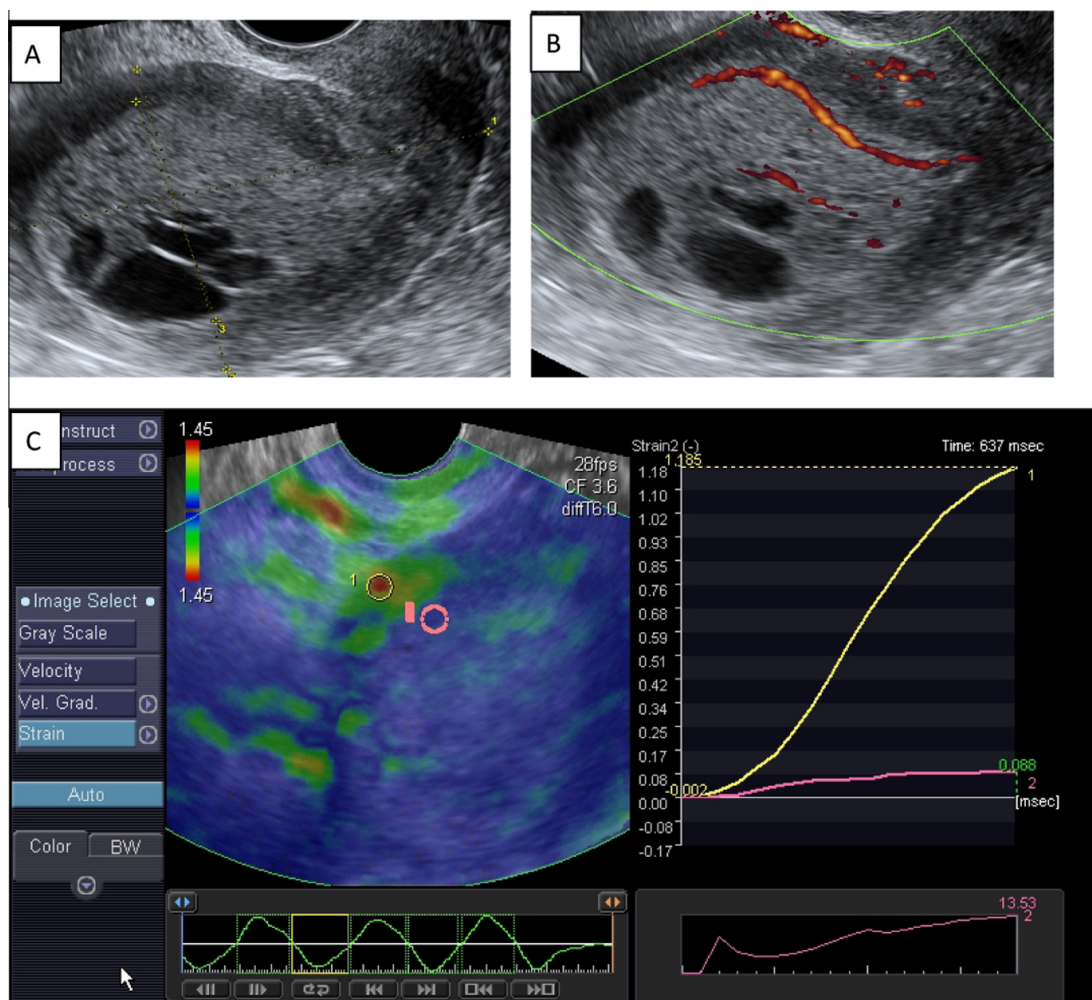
Ultrasound images of a female patient, aged 62 years with malignant thickened endometrium (confirmed to be endometrial adenocarcinoma by pathological examination). B-mode ultrasound image (A), Power Doppler image (B) and TV elastogram (C) show endometrial thickness = 34 mm with increase vascularity, dark blue color and SR = 13.53.
